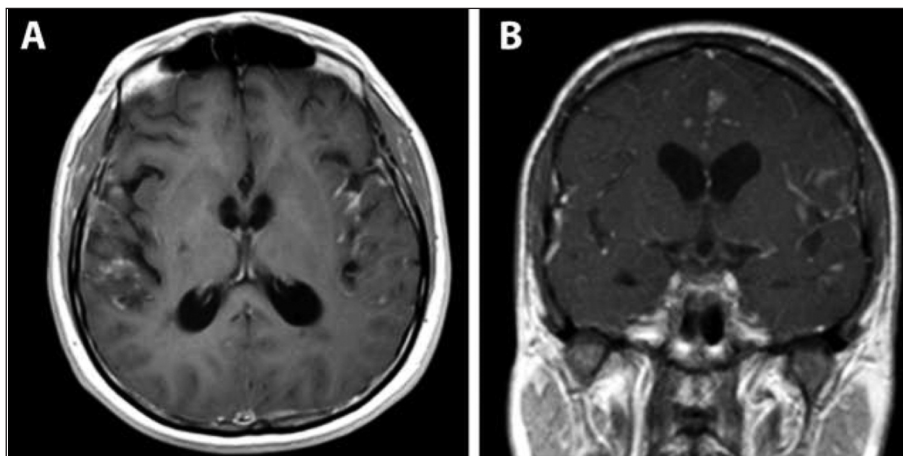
Axial MRI T1 post-contrast image, demonstrating intra-extra parenchymal contrast (A). Coronal MRI T1 post-contrast image, demonstrating intra-extra parenchymal contrast (B).
